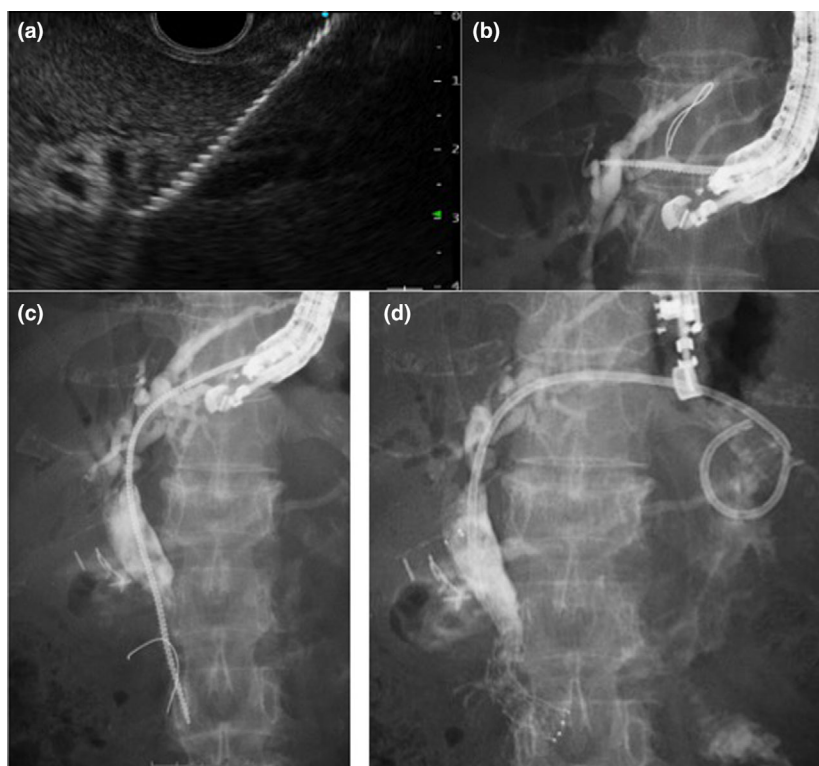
Endoscopic ultrasound-guided hepaticogastrostomy. (a) During dilation, there was no inexpedient increase in the distance between the liver and the gastric wall, which move apart from each other. (b) The scope remained stable because the operator did not have to push the dilator during dilation. (c) The distal biliary stricture could be dilated smoothly using a Tornus ES. (d) A metallic stent was placed at the biliary stricture, and a plastic stent was placed at the puncture site.
